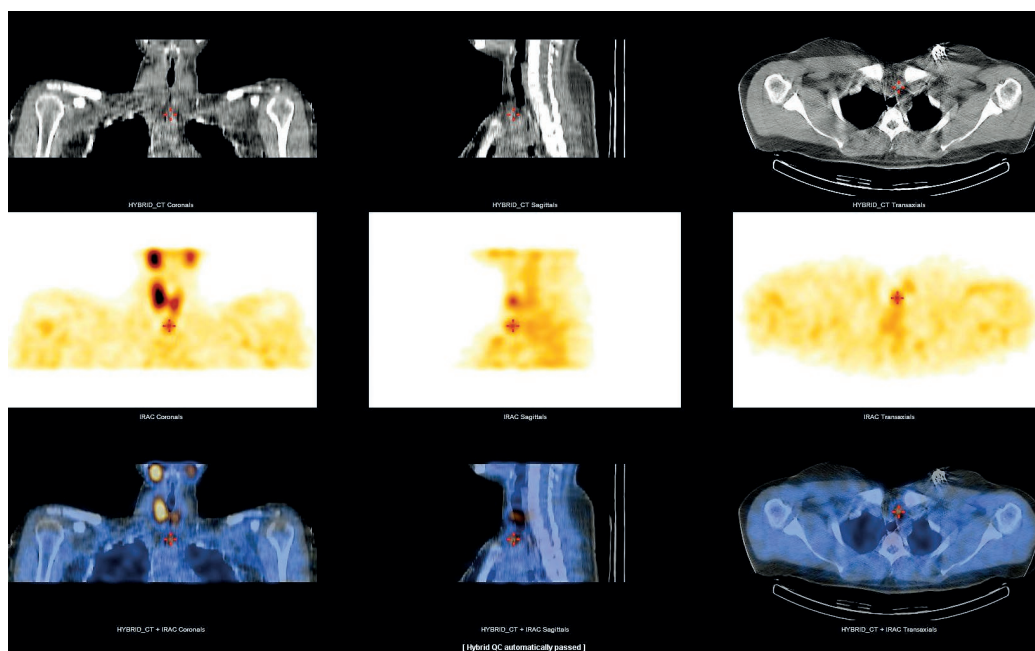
Neck ^{99m}Tc -MIBI SPECT/CT. Parathyroid adenoma is clearly visible behind the left clavicle.
